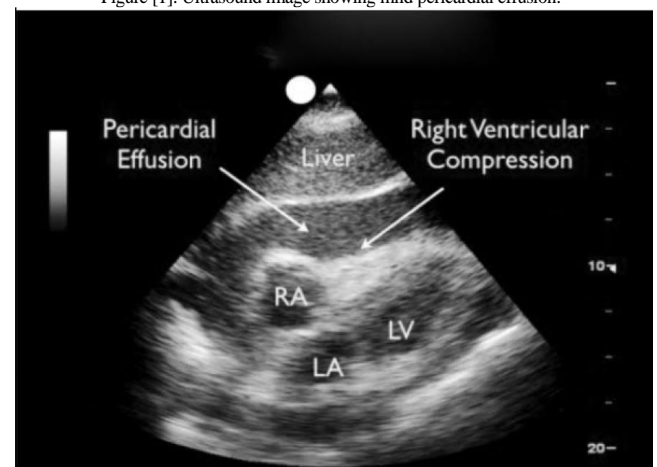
Ultrasound Image Showing Pericardial Effusion with right Ventricular Compression.
